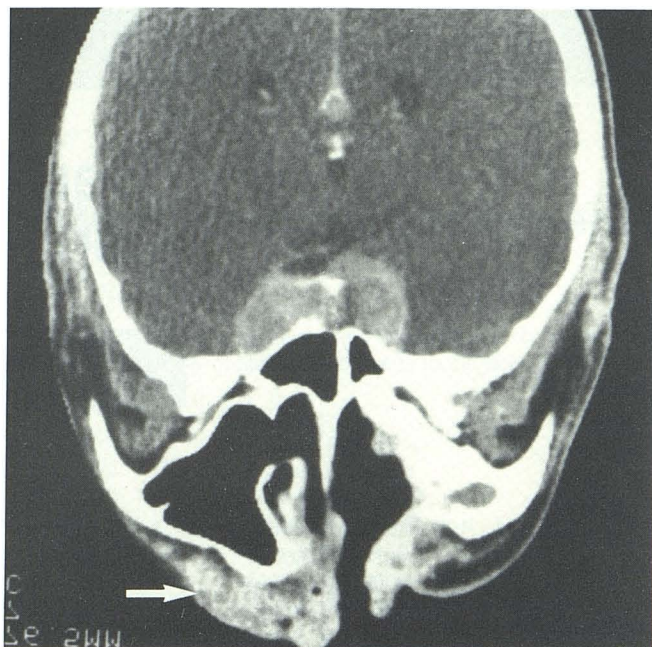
Modified coronal postcontrast CT scan reveals tumor mass in cavernous sinuses. In addition, there is biopsy-proven isolated metastatic tumor mass (*arrow*) in right side of face. Solely on the basis of CT appearance, this lesion could not be distinguished from granuloma.
